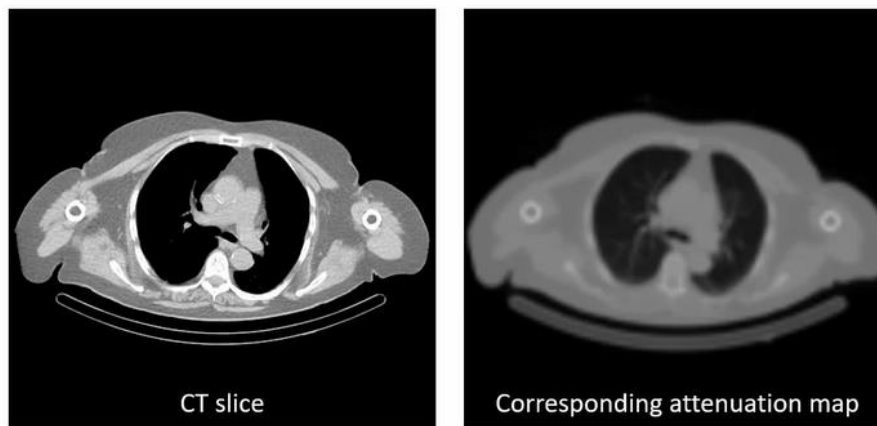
The Hounsfield Units of the CT slice (left side) are converted into attenuation coefficients for a particular gamma photon energy, creating the attenuation map (right side).
